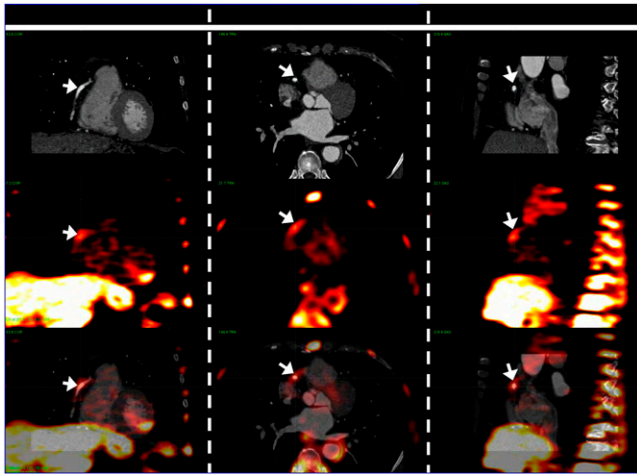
Visually apparent FDG uptake at the culprit site in a patient after percutaneous coronary stenting to proximal right coronary artery for acute myocardial infarction. Columns, left to right: Coronal, axial, and sagittal views. Rows, top to bottom: CCT only (arrows = stent), FDG PET only (arrows = uptake), coregistered CCT and FDG PET (arrows = stent).
